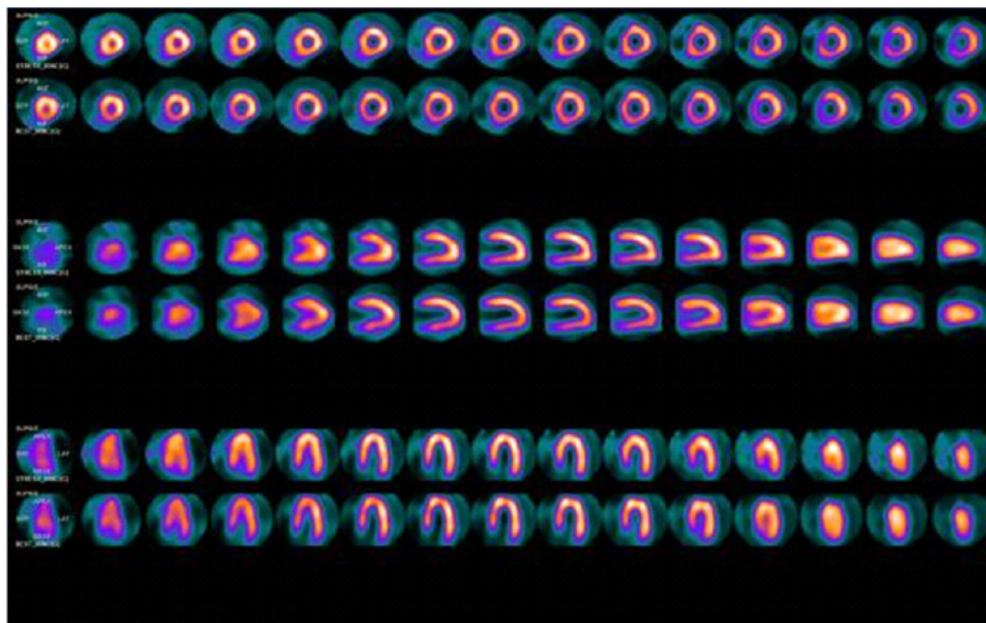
Case 8 - Myocardial perfusion scintigraphy within normality. Images acquired with dedicated cardiac equipment, equipped with solid cadmium-zinc-tellurium detectors.
